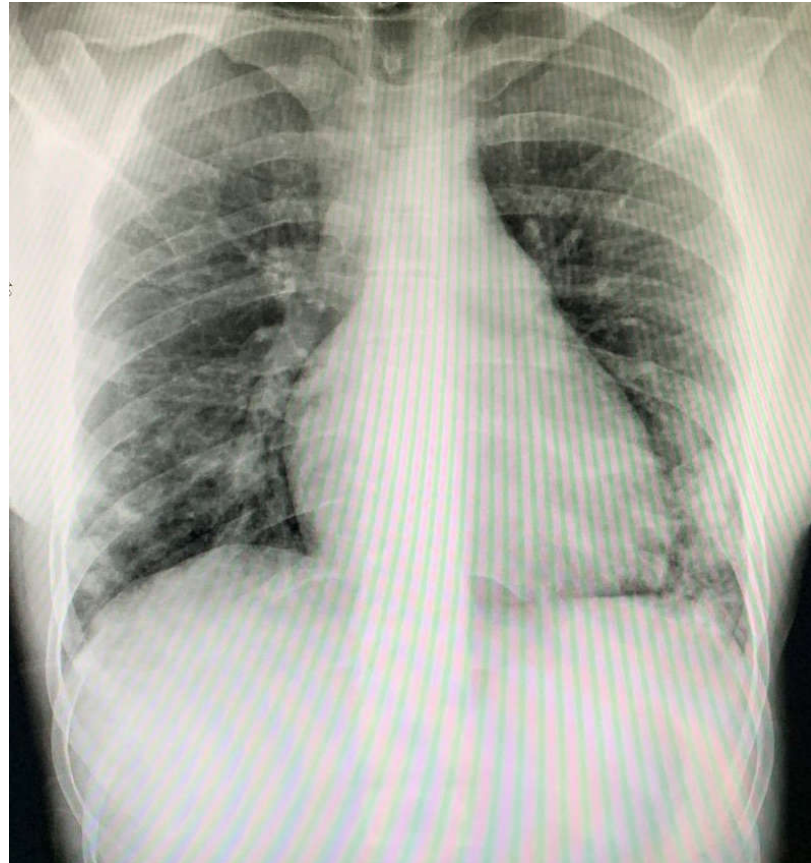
Chest X-ray showing bilateral pneumonia due to COVID-19.
